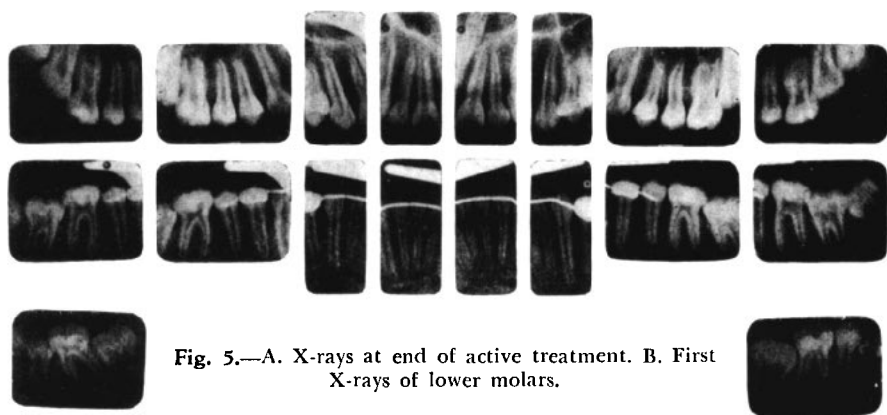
A. X-rays at end of active treatment. B. First X-rays of lower molars.
